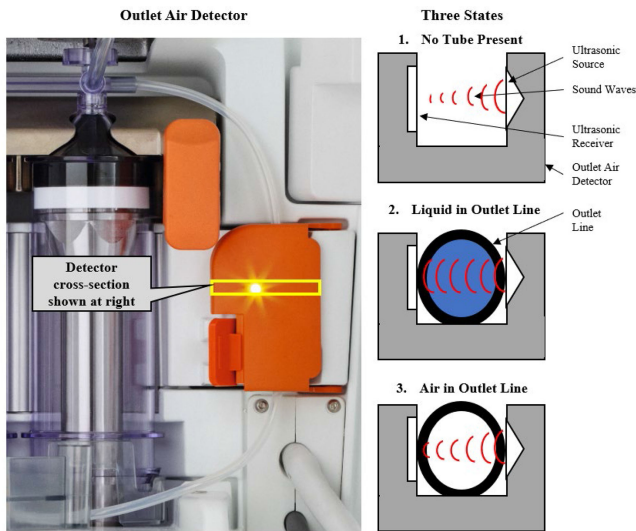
Overview of the ultrasonic outlet air detector, showing the detector design and the difference in acoustic attenuation through an outlet line filled with fluid or air. The relative size of the sound waves is exaggerated to represent acoustic power differences. Note, the entire tube is not required to be filled with air for the detector to sense attenuation differences. In addition, the LED shown (left image) is an indicator signaling that the air detector is properly closed and does not contribute to air measurement.
